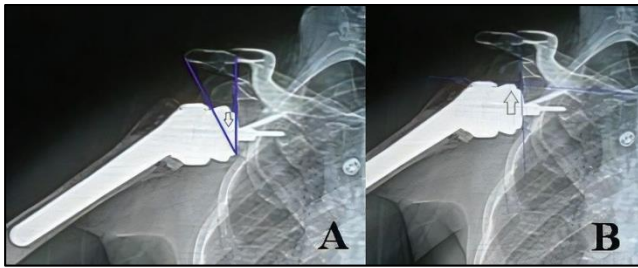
(A and B): Post-operative radiographs showing; CSA (arrow) and beta angle (arrow).
